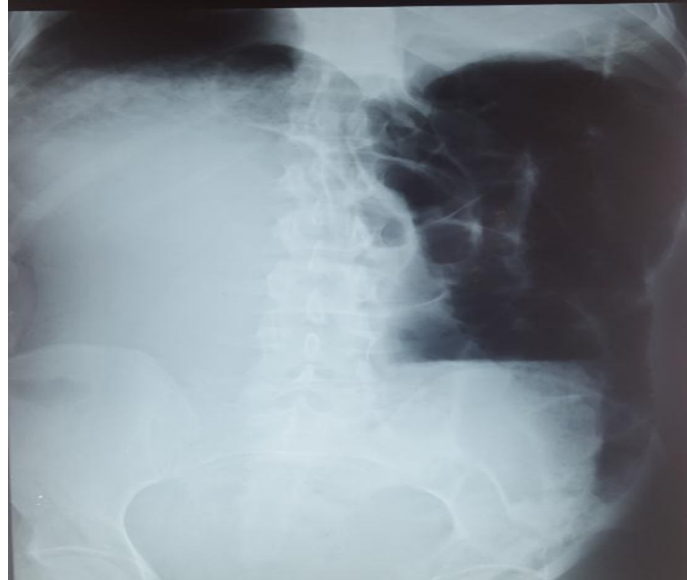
Showing in the Plane X-ray large distension of the stomach.
